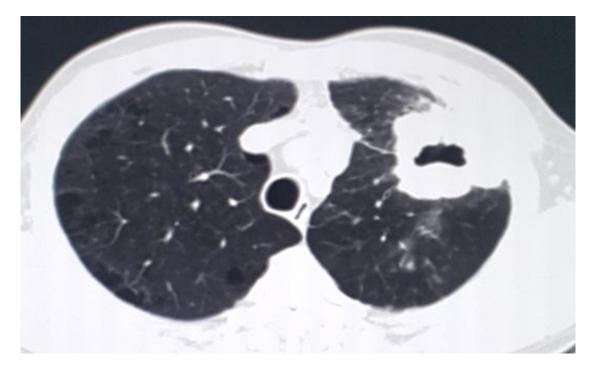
Supine pre biopsy axial CT scan of 52 year old chronic smoker. The cavitating lesion seen in the left upper lobe was confirmed to be squamous cell carcinoma
